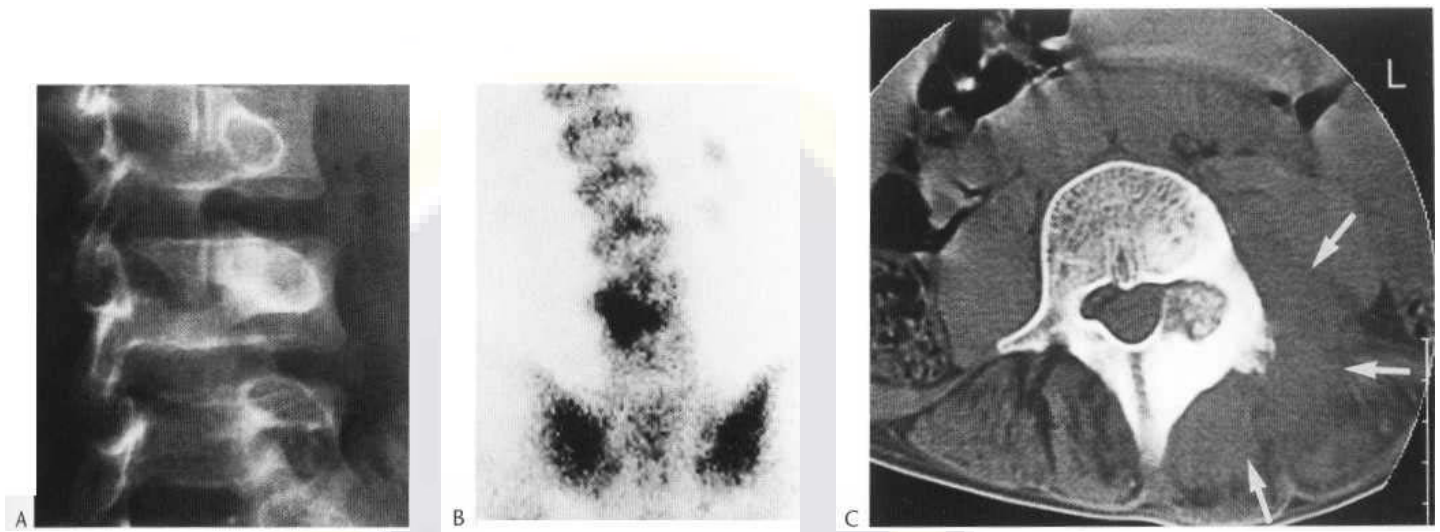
Osteoblastoma of the left pedicle and lamina of L3. (A) Conventional oblique radiograph showing expansion and sclerosis. (B) Radionuclide bone scan demonstrating extensive and marked increase in activity and a scoliosis. (C) CT section showing punctate calcification of the lesion with expansion of the pedicle and lamina and prominent dense sclerosis. Considerable soft-tissue oedema is also evident (arrows).
